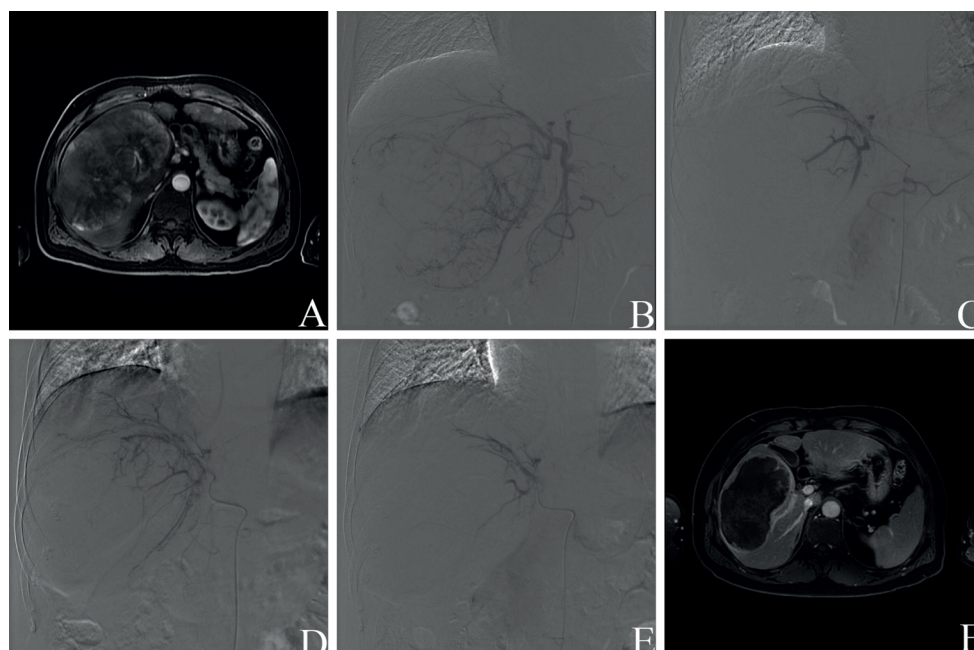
A classic case of HCC patients underwent TACE with CBATO treatment. The MRI images before TACE with CBATO treatment (A). The hepatic angiography during the first TACE with CBATO treatment (B). The hepatic angiography at the end of the first TACE with CBATO treatment (C). The hepatic arteriography at the first month after the first TACE with CBATO treatment (D). The hepatic arteriography at the end of the second TACE with CBATO treatment (E). The MRI images at the sixth month after the first TACE with CBATO treatment (F). HCC, hepatocellular carcinoma; TACE, transarterial chemoembolization; CBATO, CalliSpheres beads loading with arsenic trioxide.
